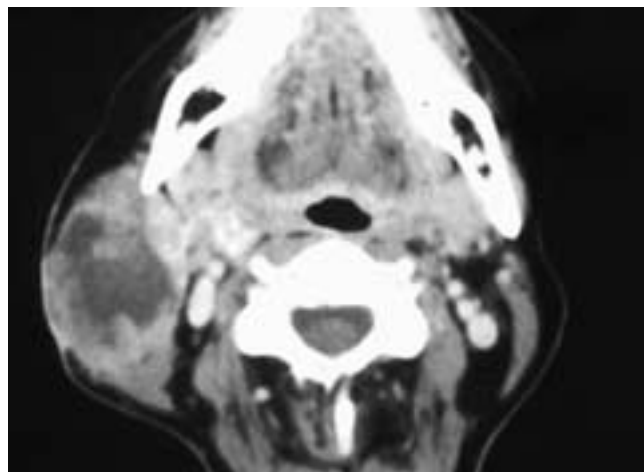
Axial contrast-enhanced CT scan shows a necrotic mass in the right parotid gland with poorly defined margins. Multiple tumor nodules are seen along the wall of the lesion. This appearance suggests a high-grade tumor. This patient had an AdCC. This is a more aggressive tumor than most of these parotid adenoid cystic carcinomas.
